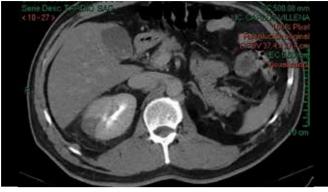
Urotomography (Uro-CT) axial section, in late phase.
